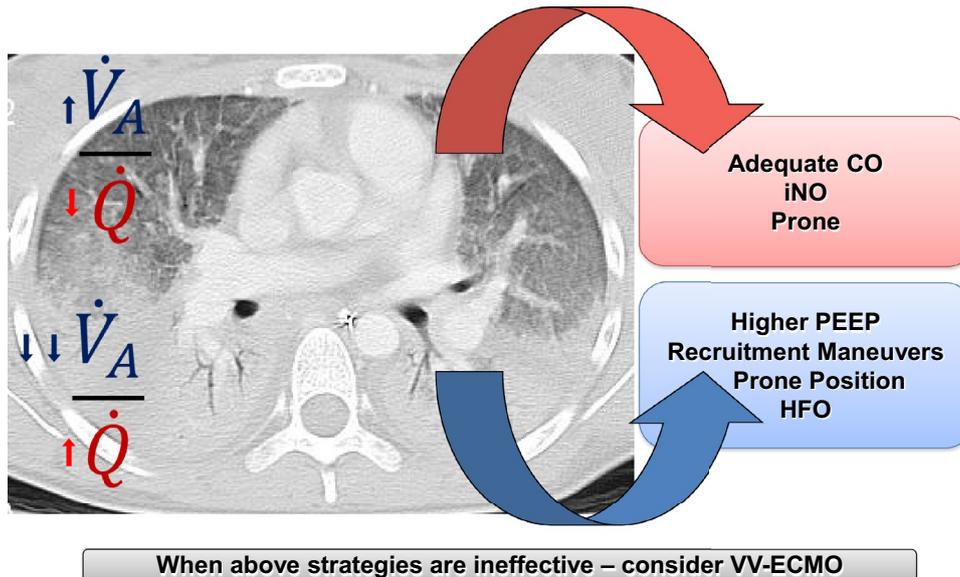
Mechanisms of action of adjunct therapies during severe ARDS on ventilation/perfusion (\dot{V}_A/\dot{Q}) distribution. Due to massive loss of aeration and increase in lung tissue as shown on the lung CT slice, hypoxemia results from large amounts of shunt and \dot{V}_A/\dot{Q} mismatch, which may be due to low alveolar ventilation (\dot{V}_A) as compared to lung perfusion (\dot{Q}) or to more lung perfusion relative to \dot{V}_A . This latter occurs when hypoxic pulmonary vasoconstriction is impaired making the lung perfusion predominant in non-aerated lung regions. To improve \dot{V}_A/\dot{Q} matching and hence oxygenation, interventions may act on both sides of the equation. By increasing perfusion in well ventilated regions, inhaled nitric oxide (iNO) and intravenous fluid challenges redistribute lung perfusion and cardiac output (CO) to well-aerated areas and better match \dot{V}_A/\dot{Q} . PEEP can increase aeration in non- or poorly ventilated areas thereby improving \dot{V}_A/\dot{Q} . CO may decrease with PEEP, which also contributes to \dot{V}_A/\dot{Q} improvement. High frequency oscillation and recruitment maneuvers improve \dot{V}_A/\dot{Q} by increasing \dot{V}_A . Prone position increases \dot{V}_A in the vertebral lung regions where \dot{Q} remains prevalent and, furthermore, makes the distribution of \dot{V}_A/\dot{Q} homogeneous across the lung
